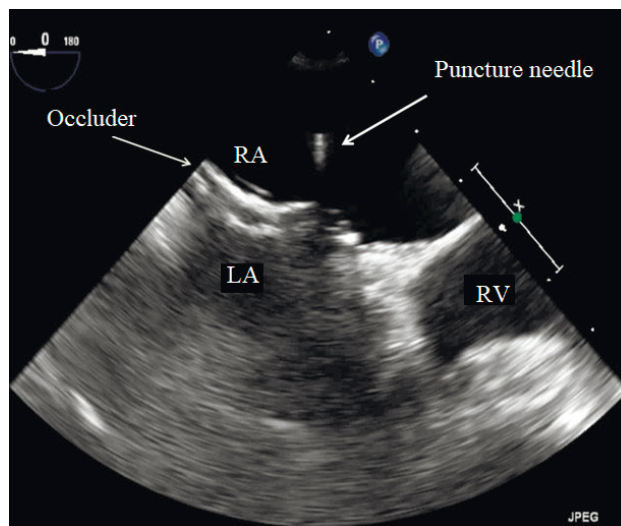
The transseptal puncture under TEE monitoring: the heart chambers, the implanted occluder, the atrial septum, the puncture needle is visualized. TEE - transesophageal echocardiography, RA - right atrium, LA - left atrium, RV - right ventricle
